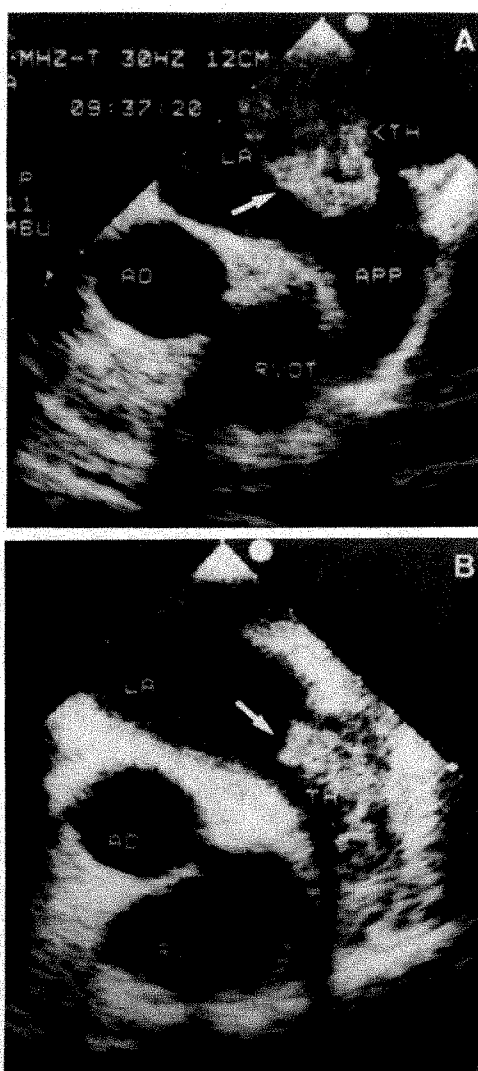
Transesophageal echocardiography showing large left atrial thrombus (TH) (arrow) attached to left atrial posterior wall in patient (A), and left atrial appendage (APP) thrombus with mobile part (arrow) extending into left atrial cavity in another patient (B). Both cases were judged to be inappropriate for percutaneous transvenous mitral commissurotomy (PTMC). AO = aorta; LA = left atrium; RV = right ventricle; RVOT = right ventricular outflow tract.
